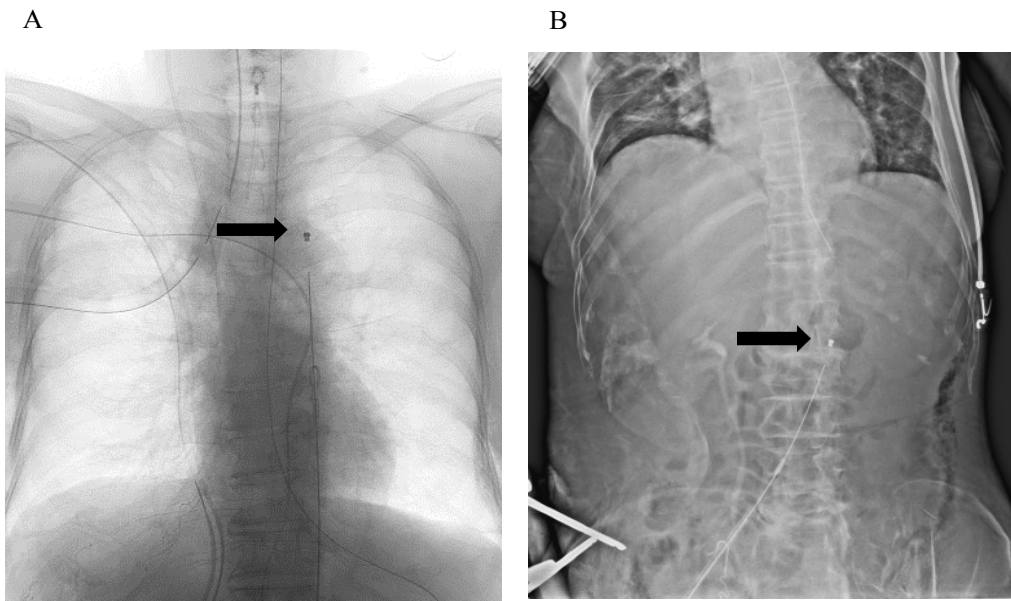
Position confirmation of the balloon catheter by fluoroscopy or portable radiography.
